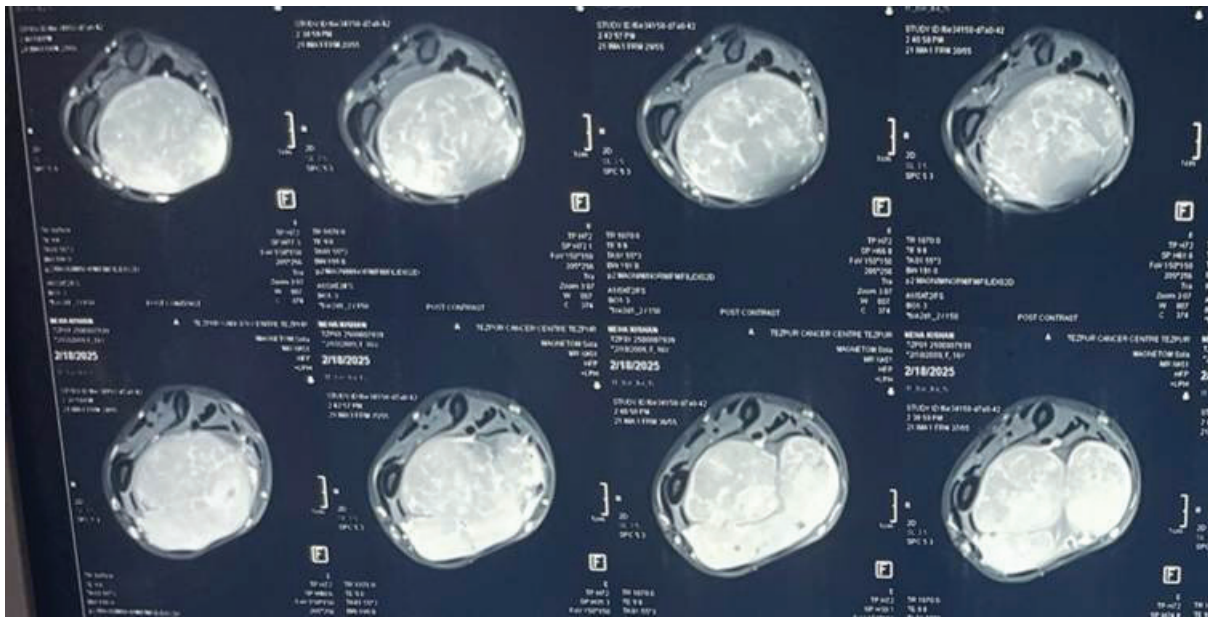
MRI of the right forearm demonstrating a well-defined, elongated, multilobulated lesion along the course of the median nerve within the flexor compartment.
